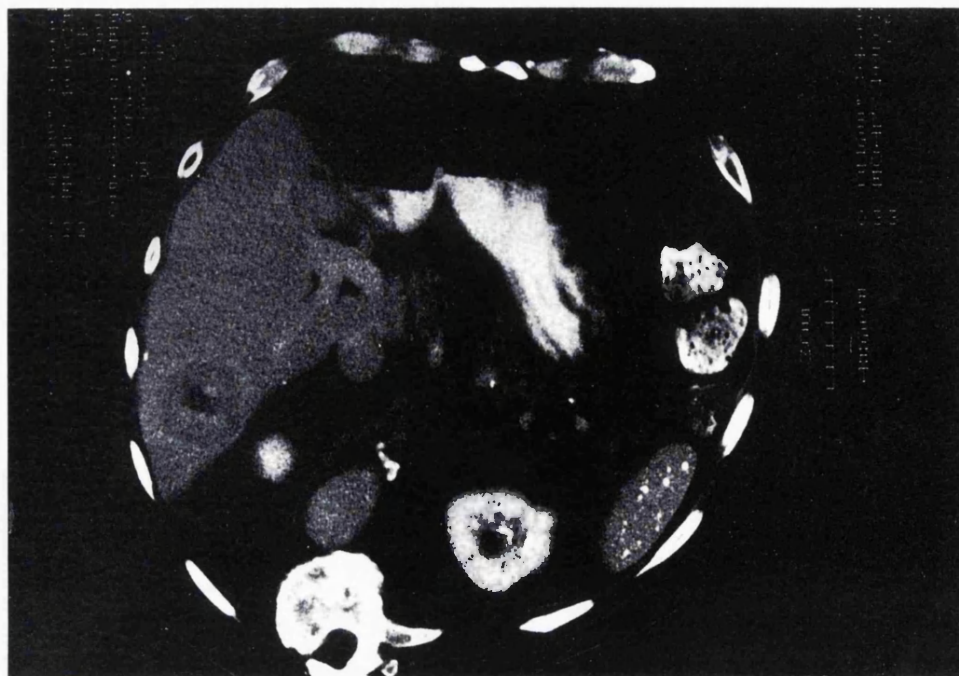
Computed tomography scan showing recurrent tumour in segment VI of liver.
